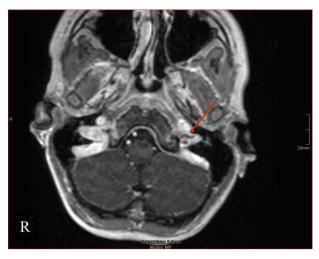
Magnetic resonance imaging of the brain on day 1, transversal, T1, with contrast. Red arrow: filling defects of the left internal jugular vein as a sign of thrombosis. (For interpretation of the references to color in this figure legend, the reader is referred to the web version of the article.)
